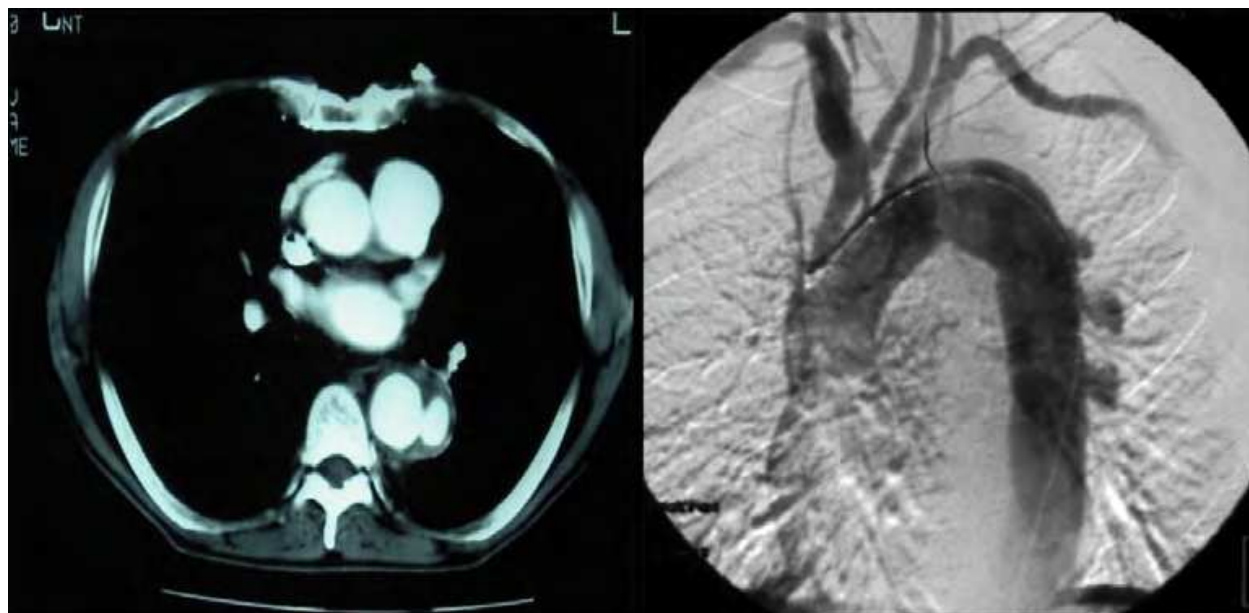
Case 6. Left: Computed tomography scan revealing a 20 x 10-mm penetrating aortic ulcer with an intramural hematoma. Right: Aortography showing 3 penetrating ulcers in the descending thoracic aorta.
